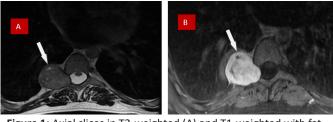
Axial slices in T2-weighted (A) and T1-weighted with fat saturation (B) of a spinal MRI before (A) and after the injection of the contrast agent (B).
